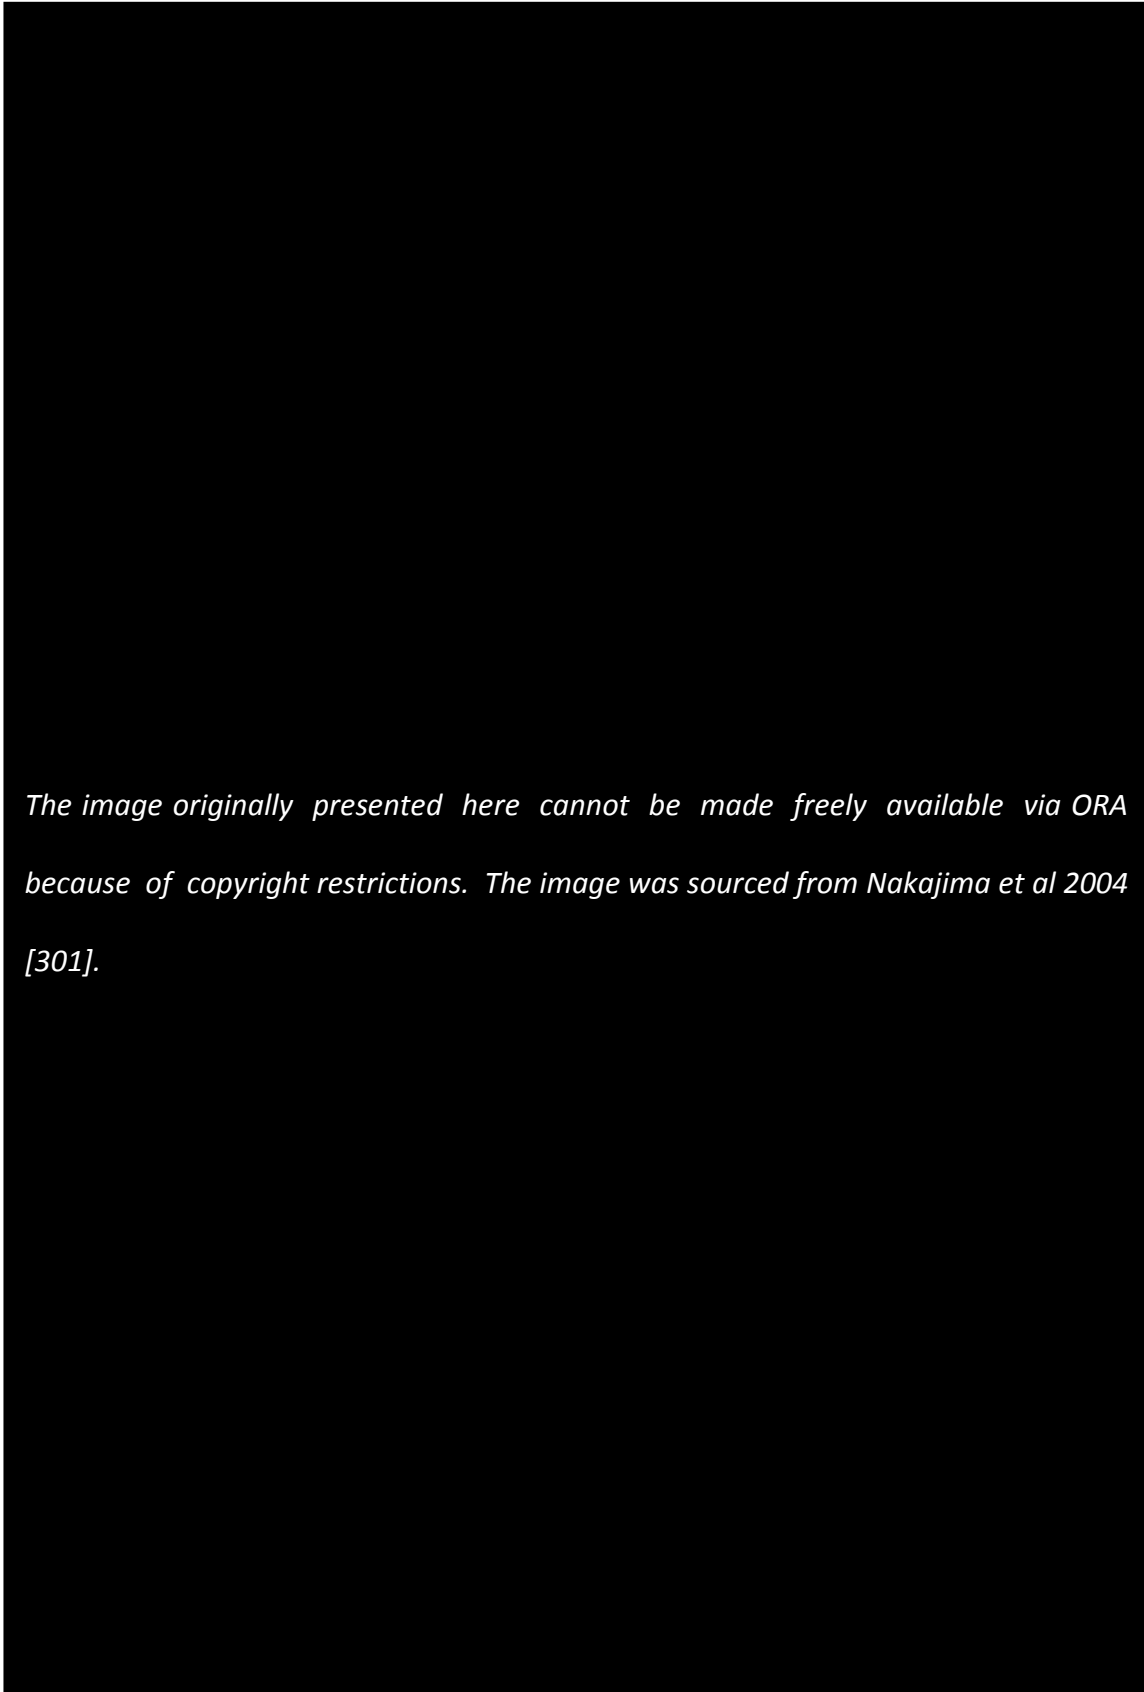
5 Top down MRI view of supraspinatus tendon (shown in white), and its attachment to the humerus (shown in grey) and supraspinatus muscle (shown in dark grey) when the arm is in various positions: Internal Rotation (IR), no rotation (Neutral) and External Rotation (ER), at 0, 30 and 60 degrees of abduction (ABD). The position of the arm can be seen to have a significant influence on the shape of the supraspinatus tendon. Taken from Nakajima et al 2004 [301].
